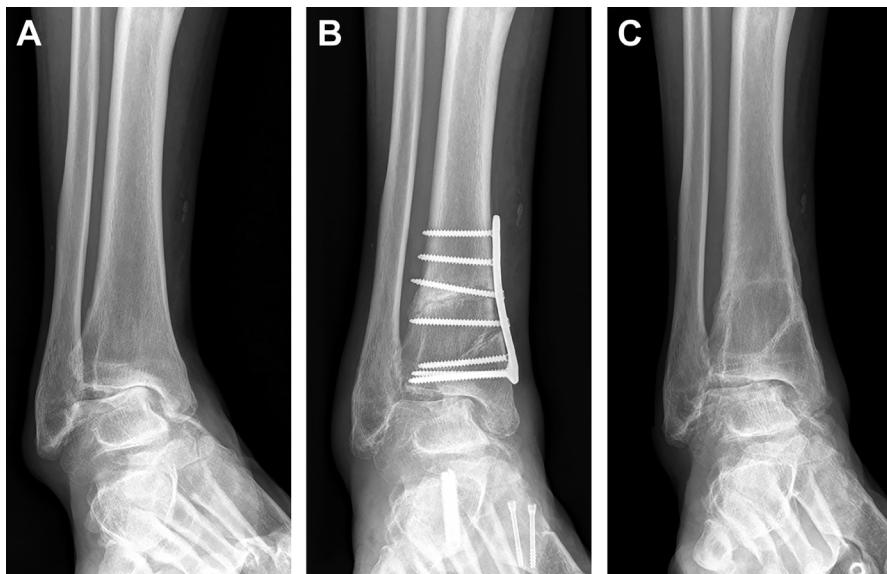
Double osteotomy of the distal tibia. An intraarticular open-wedge osteotomy is performed to restore the distal articular surface, in addition to an open-wedge osteotomy to medialize the loading axis of the tibia. A 52-year-old male sports teacher with stage 3a OA. AP radiographs showing (A) preoperative obliteration of the joint space at the medial corner in the roof of the dome of the talus with impaction into the plafond and an angle of talar tilt on weight-bearing of 11°. (B) Four months after surgery, an improvement of talar tilt to 7° is seen, with remaining medial joint obliteration, and (C) 5 years postoperatively, no change can be seen. Despite this disappointing radiographical result, the patient was satisfied with the obtained result and was still able to perform his profession as a sports teacher.
